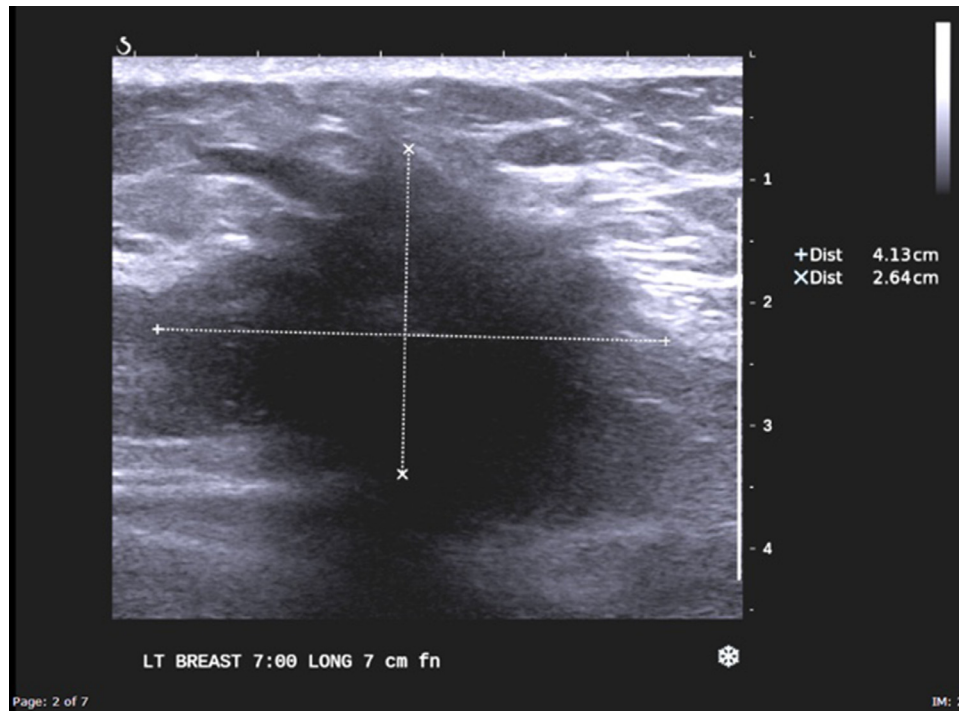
Ultrasound – 4.1 x 2.6 cm hypoechoic mass with angular margins in lower inner quadrant of left breast, 7:00 position 7 cm from nipple.
